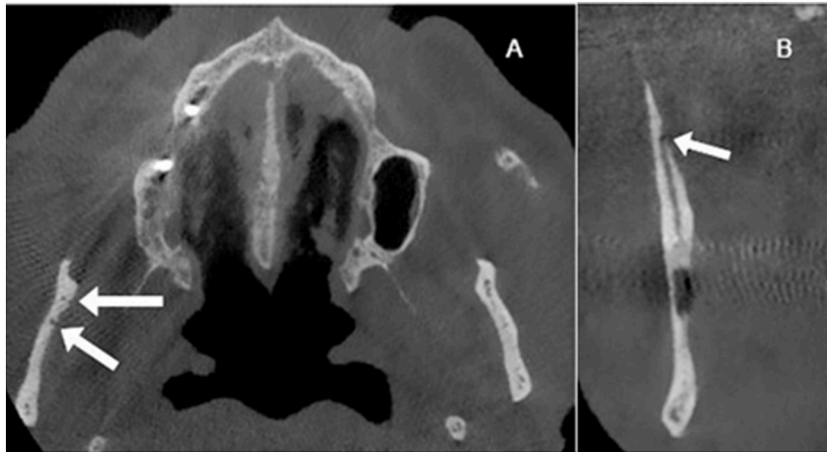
CBCT axial image arrowheads point to the coronoid canal in A, CBCT coronal section image arrowheads point to the coronoid canal in B.
